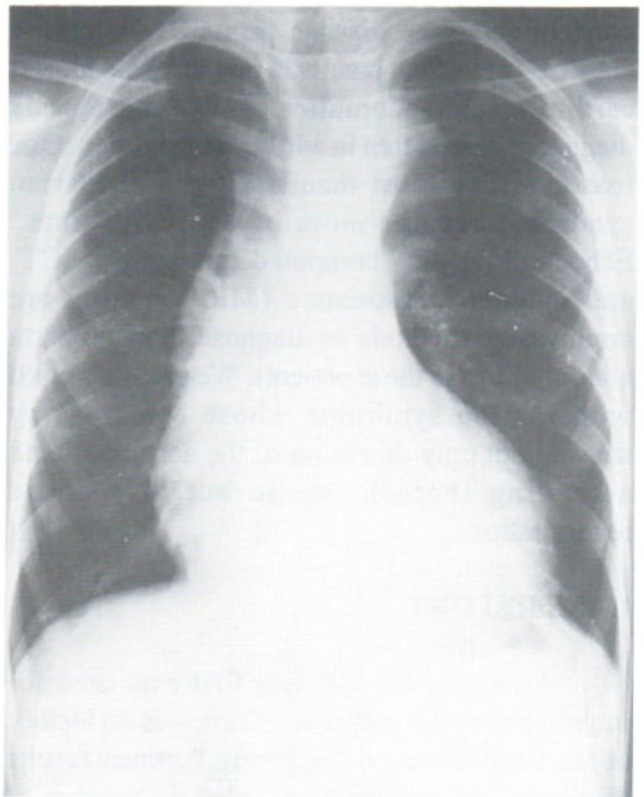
Frontal chest radiograph shows cardiomegaly and dilatation of the ascending thoracic aorta.
